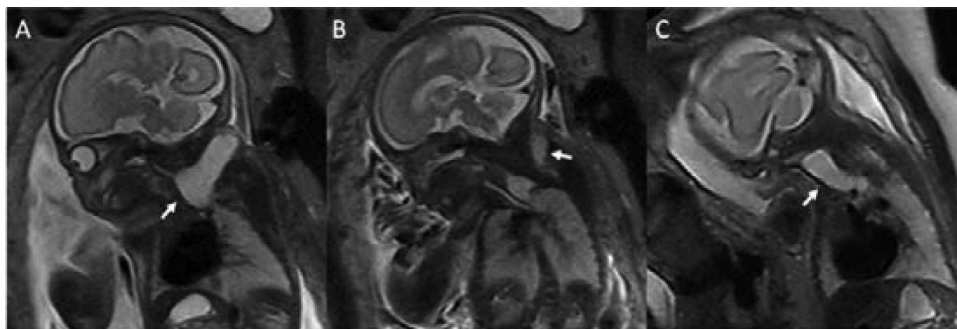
Sagittal T2-weighted fetal MR images of a fetus with a cervical thymic cyst (A-C). The images show a well-defined, thin-walled, unilocular cystic structure in the left lateral neck. The images demonstrate the typical location of the cyst (A) adjacent to the carotid space (B) and the continuity with the mediastinal thymus (C).
